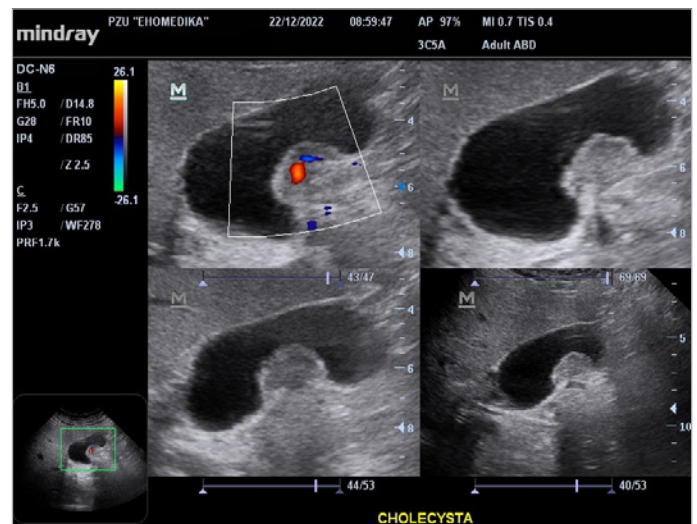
Ultrasound examination finding.
